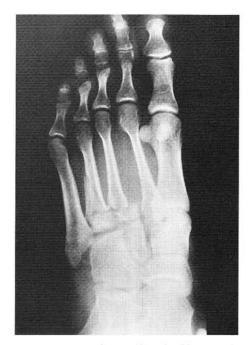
Prereduction lateral oblique radiograph
